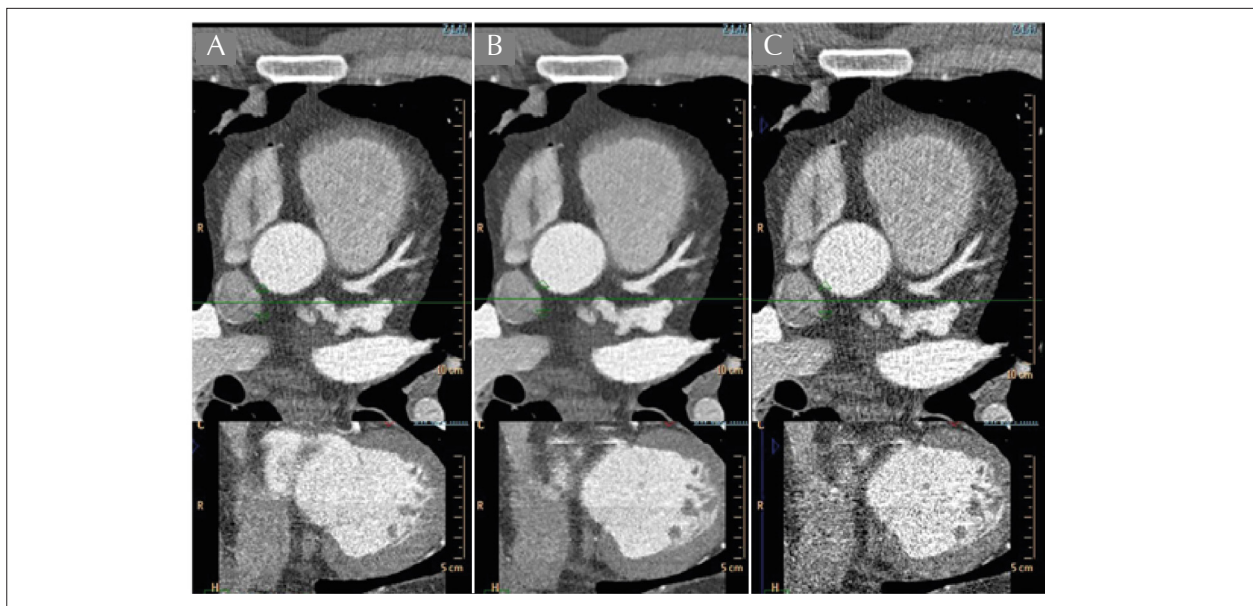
Axial and coronal sections of coronary computed tomography angiography showing different signal-to-noise ratios and the resulting quality of the images with different reconstruction techniques in an image acquired using a prospective technique and low radiation dose (2.3 mSv). Iterative reconstruction level 4 (A), iterative reconstruction level 7 (B), and the old and traditional filtered back projection (C).
